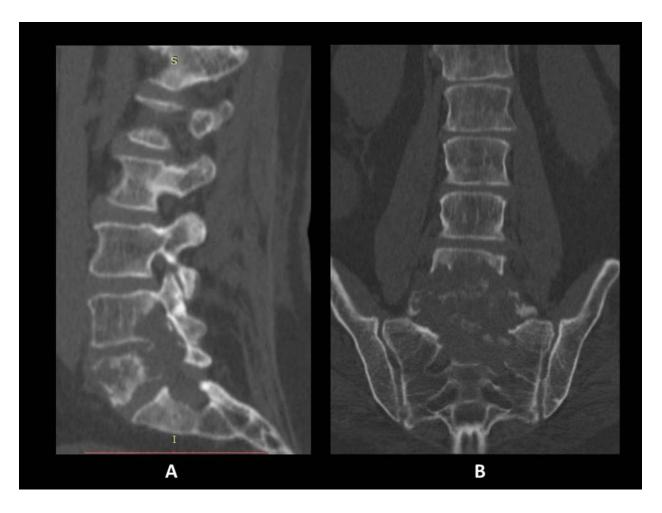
Chordoma. Sagittal (A) and coronal (B) computed tomography reformation reveals expansive lesion with scalloped borders, with amorphous calcifications in the tumor matrix and partial destruction of the upper sacrum.
